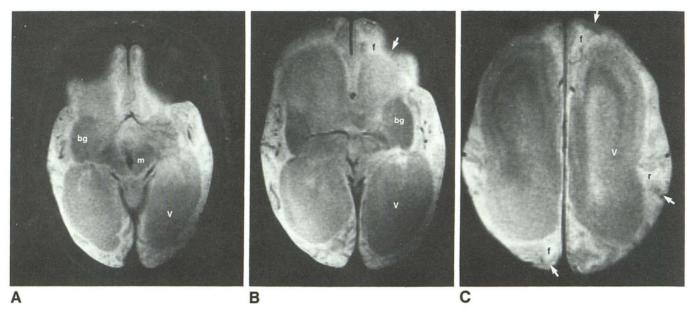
Case 7: 27-month-old girl. Axial MR images (3000/70) show marked ventricular dilatation (v) compatible with severe cerebral atrophy. Decreased signal intensity is limited to midbrain (m) and basal ganglia (bg) regions, indicating marked delay in progress of myelination [14]. White matter within forceps major and minor (f), corpus callosum, corona radiata (r), and centrum semiovale is abnormally hyperintense relative to thin cortical mantle (*arrows*). Follow-up examination at 38 months (not shown) demonstrated no change in degree of volume loss and myelination delay.
